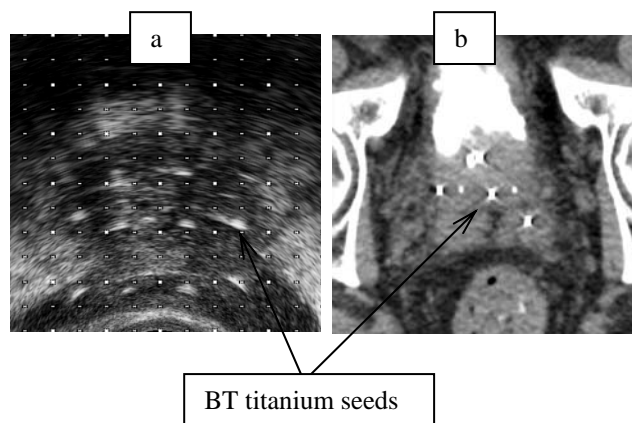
Post-implant axial images of the prostate (Base) with (a)-ultrasound, (b)-computer tomography.
